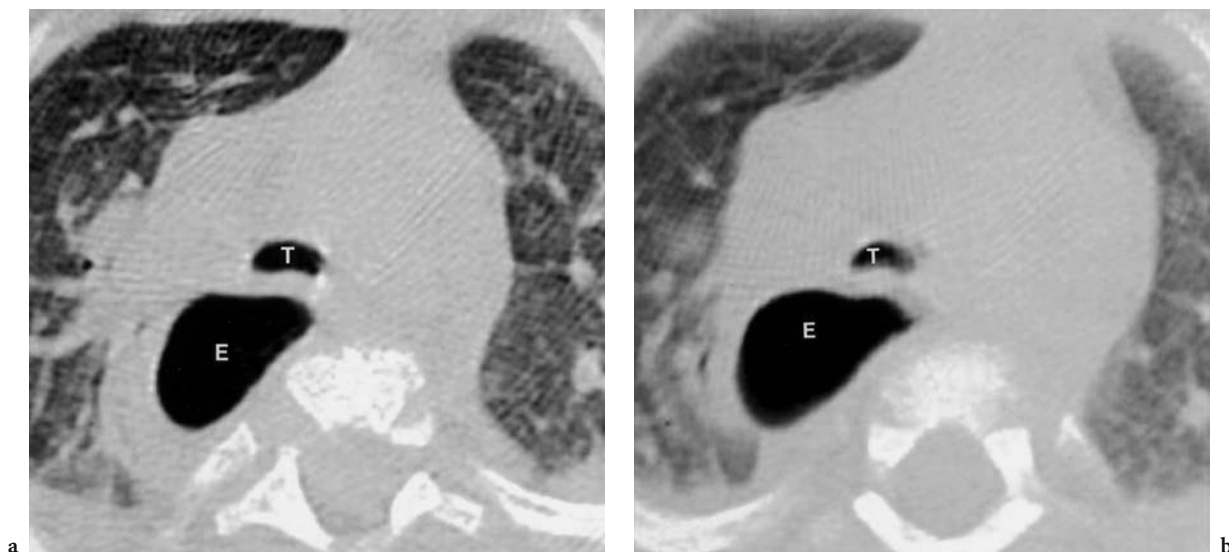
Tracheomalacia in a 1-month-old girl who had undergone an esophageal pull-through for repair of esophageal atresia and who had marked dyspnea on attempts to extubate. The patient was intubated during the CT scan, allowing images to be obtained in inspiration and expiration. A: CT scan during end inspiration and B: during end expiration demonstrates a dilated esophagus (E) and marked collapse of the intrathoracic trachea (T), consistent with tracheomalacia, which was confirmed at fiberoptic bronchoscopy
